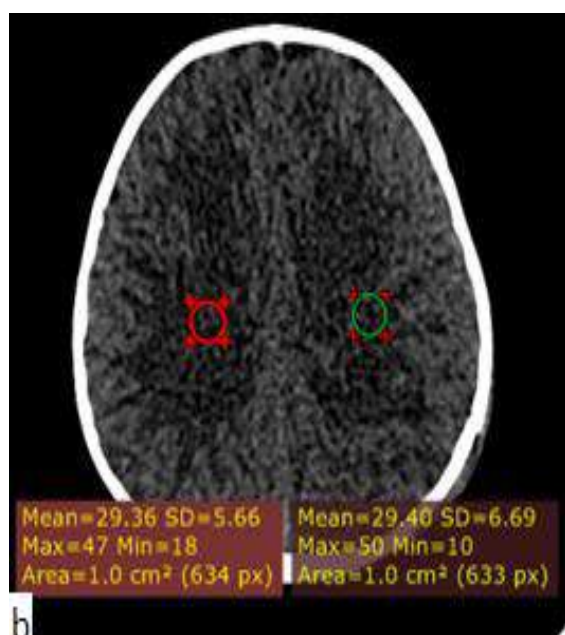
Axial CT image at the level of centrum semiovale to show the objective analysis using region of interests and measuring the average density.
